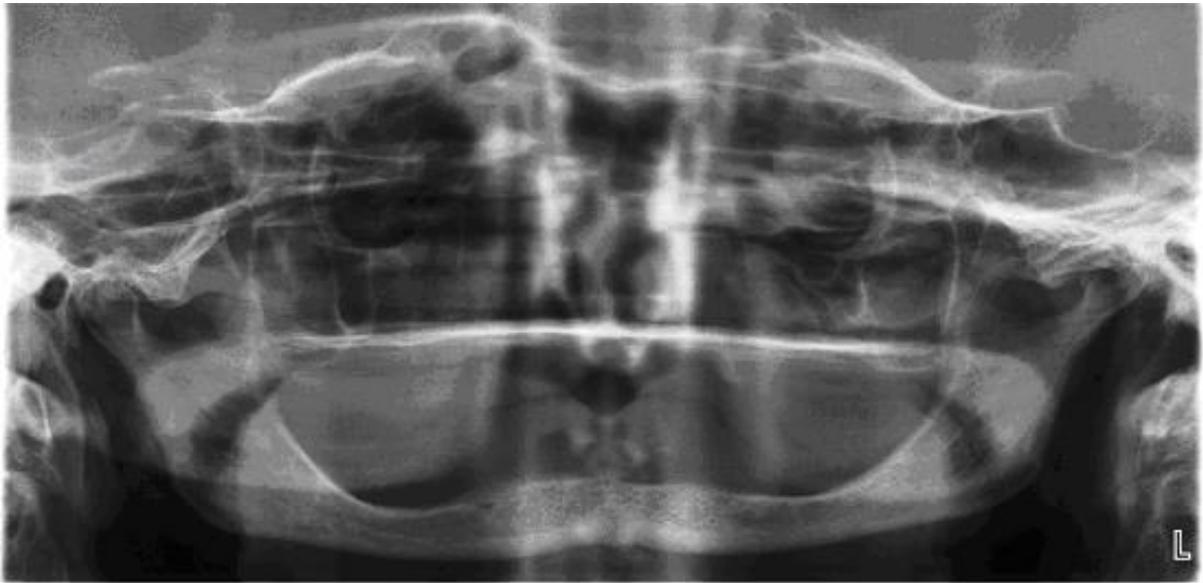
Orthopantomogram (OPG) indicates severely reduced mandibular bone height and enlarged maxillary sinuses.
